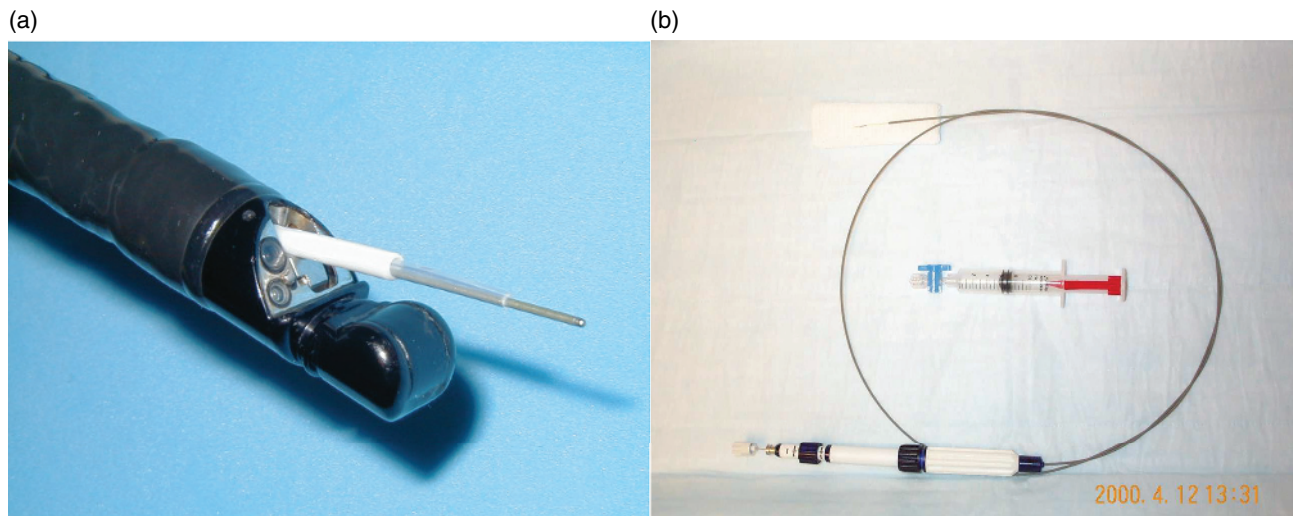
(a) and (b) Endoscopic ultrasound endoscope and guided fine-needle aspiration (EUS-FNA) device.
